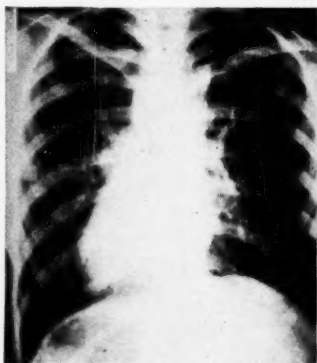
A chronic form of miliary tuberculosis has been described. This patient first became sick in October, 1922. Early in November this radiograph was made. At this stage no definite miliary tubercles could be seen.
